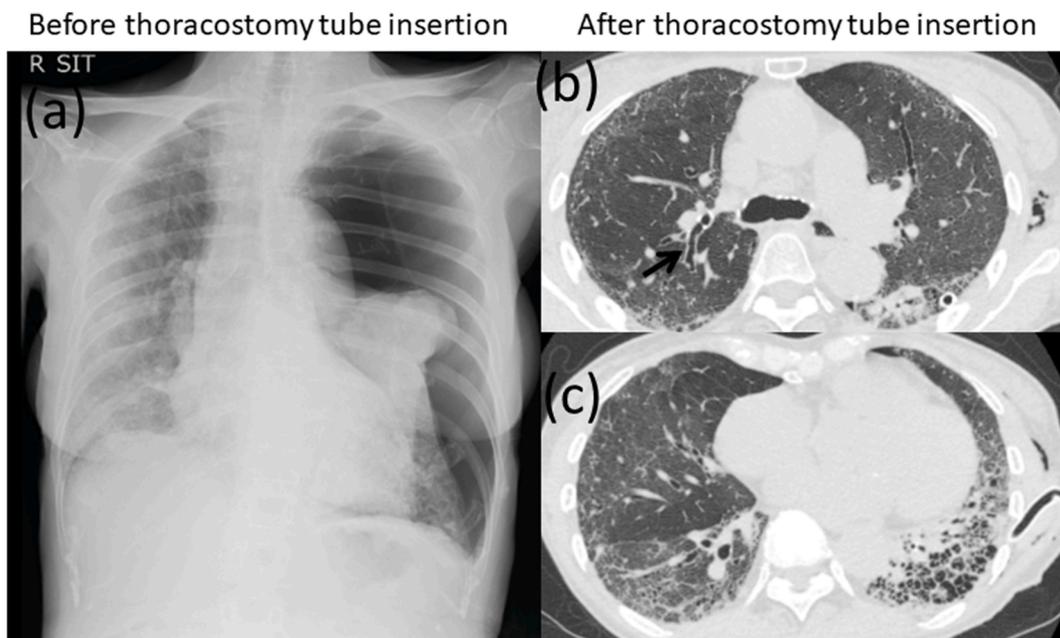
Radiological findings on admission. (a) Chest radiograph on admission shows left-sided pneumothorax with collapsing rate of 55 %. (b, c) Computed tomography after insertion of thoracostomy tube shows traction bronchiectasis (arrow), ground-glass opacity (b) and honeycomb appearance on bilateral basal lungs (c). Multiple consolidations were also seen in subpleural lesions (b, c).
